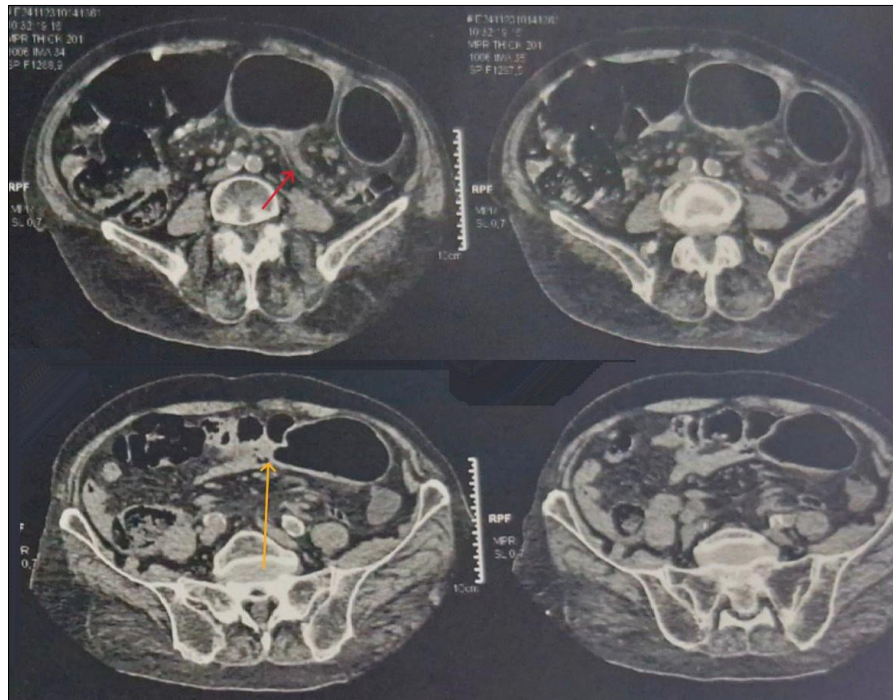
CT scan showing the vascular whirl sign (red arrow) and the convergence of the two colonic limbs (yellow arrow)
